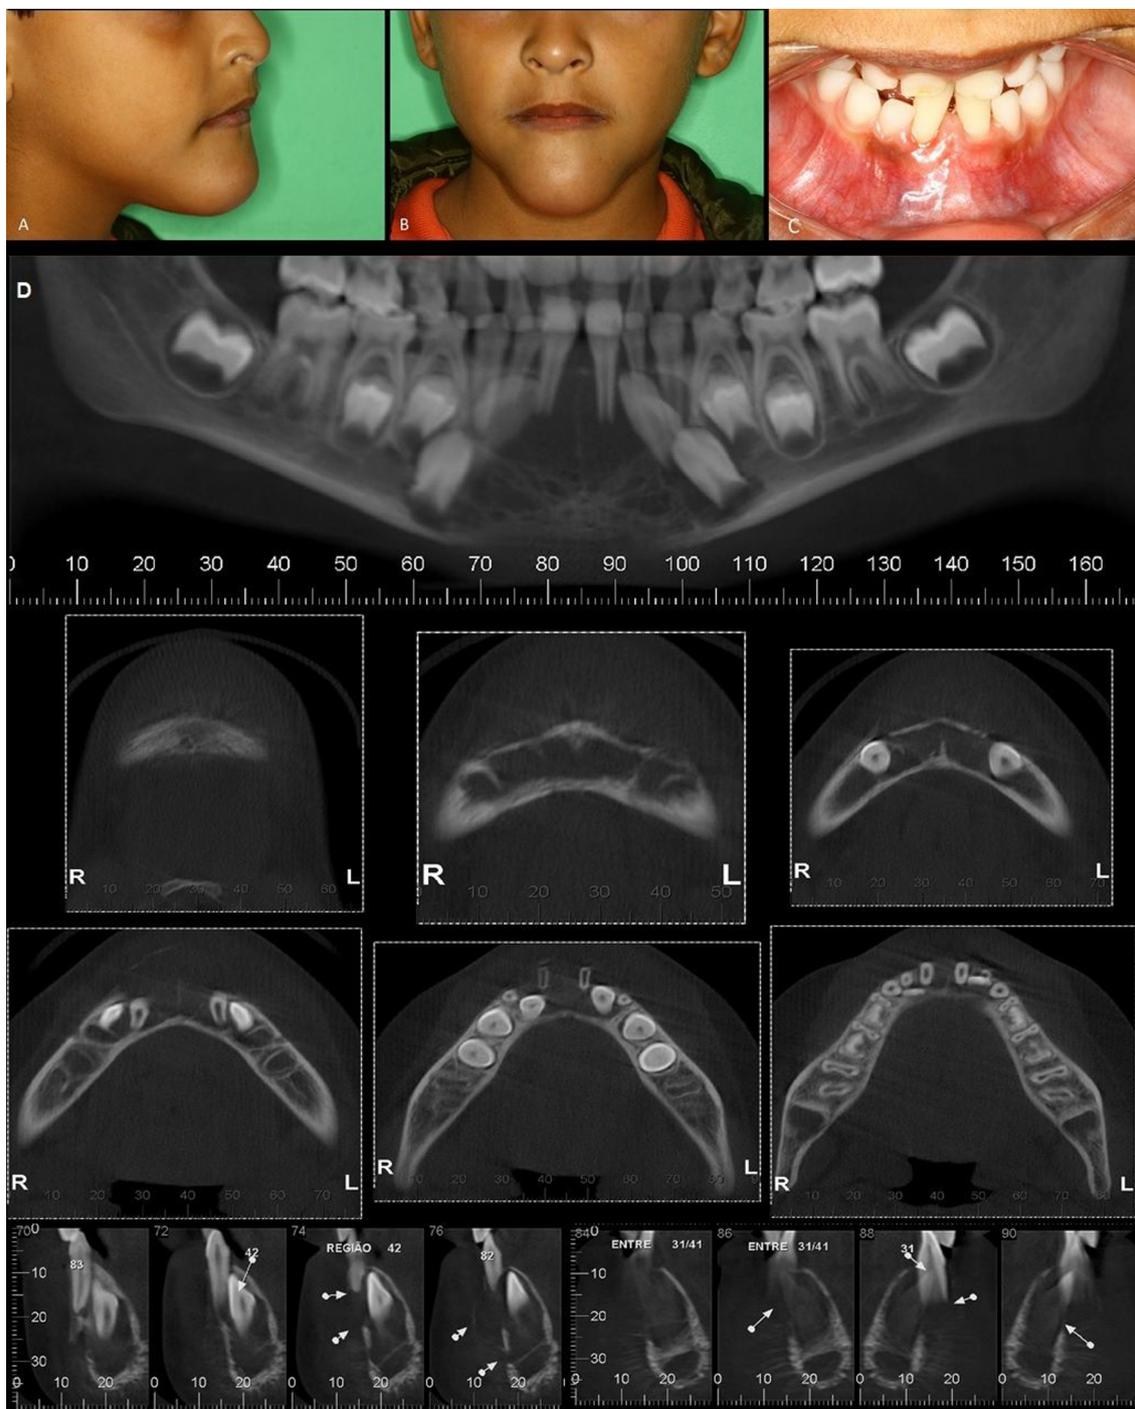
Extraoral and intraoral view. A/B: Growth affecting the chin region, lateral and frontal view. : Displacement of the central lower incisors and enlargement of the anterior mandible region. D: Cone beam computed tomography. Panoramic reconstruction shows an osteolytic lesion measuring around 4 cm of extension. Axial sections present disruption of the buccal cortical bone and parasagittal sections show both moth eaten aspect and sunburst phenomenon.
